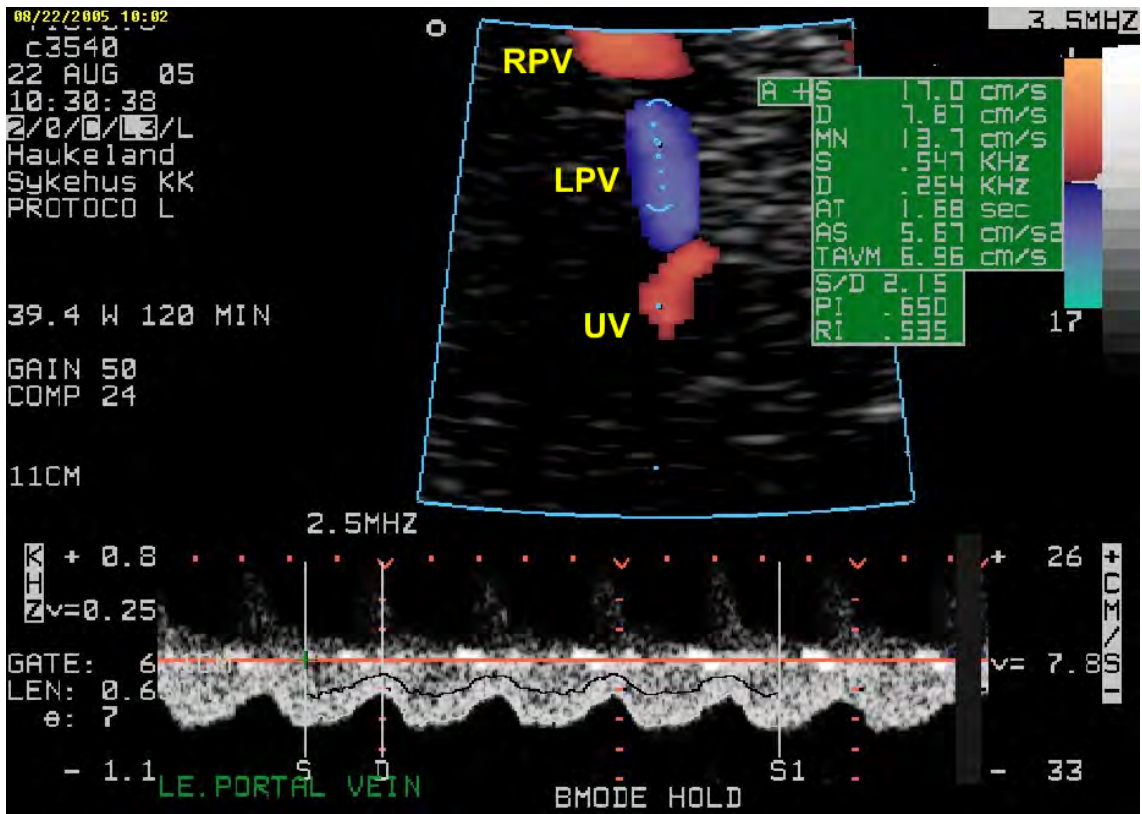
Pulsed Doppler recording of reversed flow in the left portal vein in a normal pregnancy at 39+1 weeks of gestation. UV: umbilical vein, LPV: left portal branch, RPV: right portal branch
